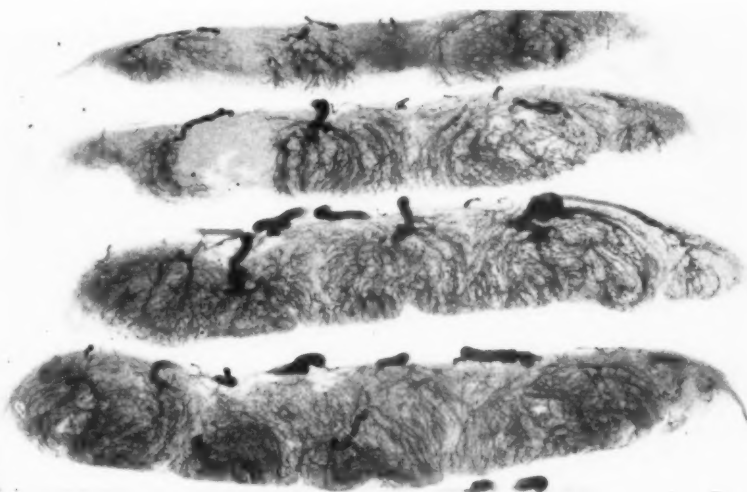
Cross-section roentgenogram of Fig. 5, showing circulatory arrest due to infarct formation.
